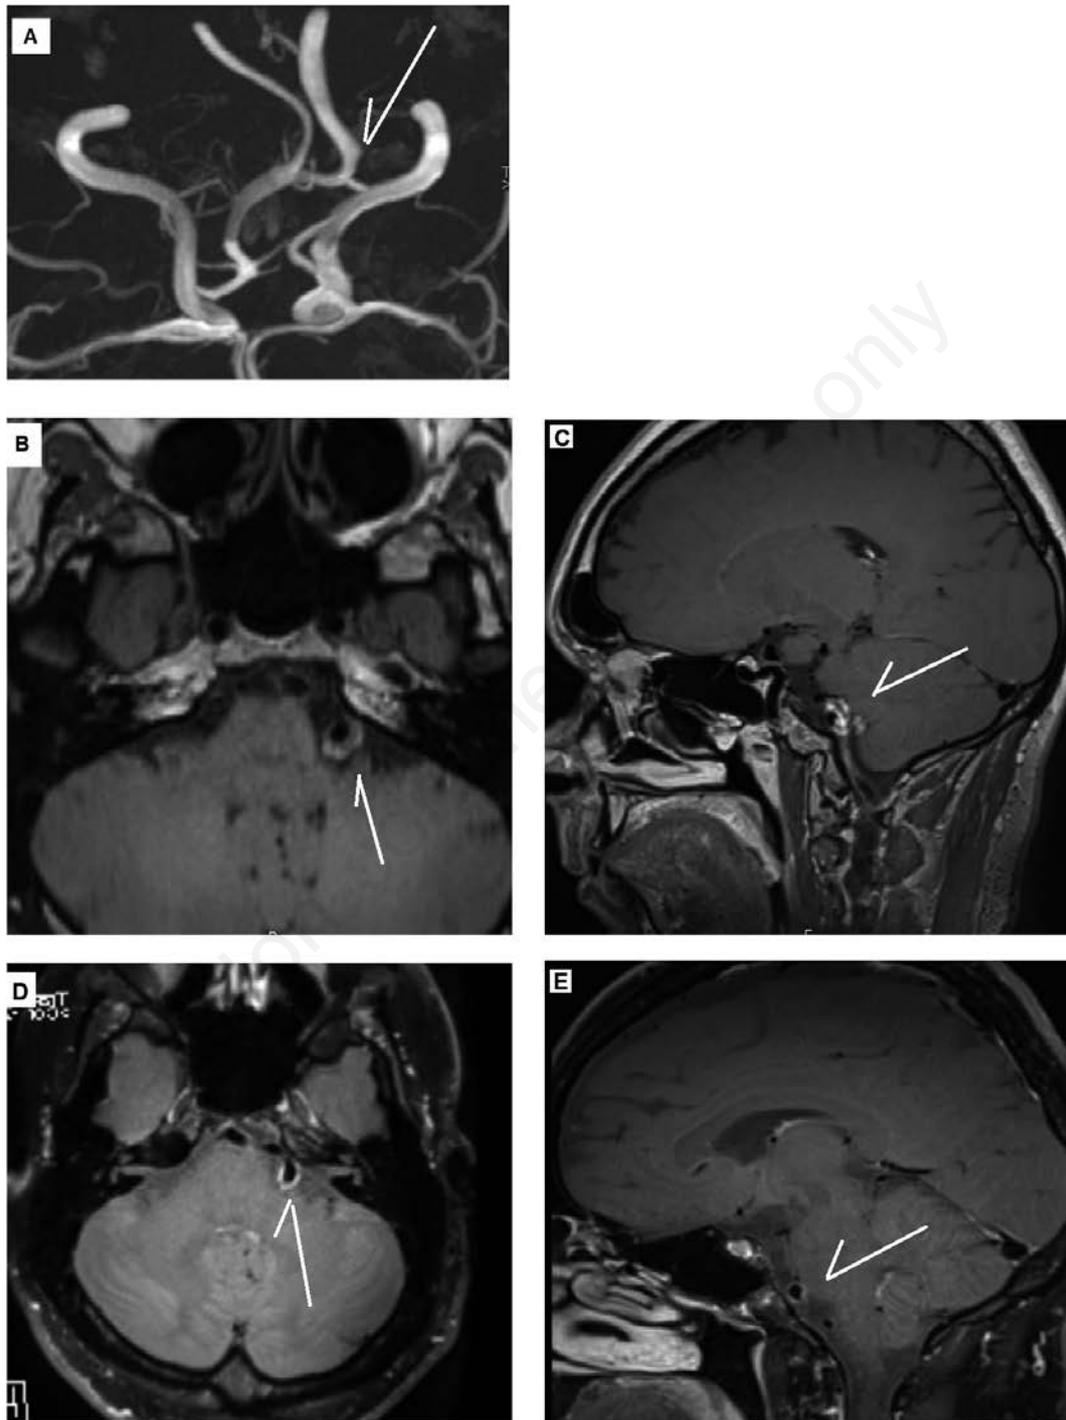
47 y.o. male with fusiform aneurysm of the vertebral artery: A) CTA reconstruction showing the dilated vertebral artery; B) initial black blood MRI showing a strong contrast enhancement of the aneurysm wall (transverse section); C) same as panel B (sagittal section); D) 8 months after Aspirine treatment shows a decrease in aneurysm size with less contrast enhancement; E) same as panel D (sagittal section).
